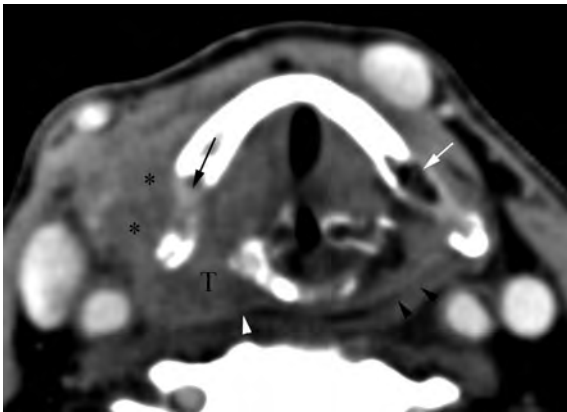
Axial contrast-enhanced CT image through the arytenoid cartilage level demonstrates replacement of the normally seen fatty bone marrow (*white arrow*) by soft tissue density (*black arrow*) caused by bone marrow replacement of this portion of the thyroid cartilage by a pyriform sinus cancer on the right (*T*). Note the abrupt cutoff of the submucosal fat planes caused by the tumor on the *right (white arrowhead)* when compared to their normal appearance on the *left (black arrowheads)*. The tumor also wraps around the posterior border of the thyroid cartilage to involve the strap muscles (*asterisks*)
